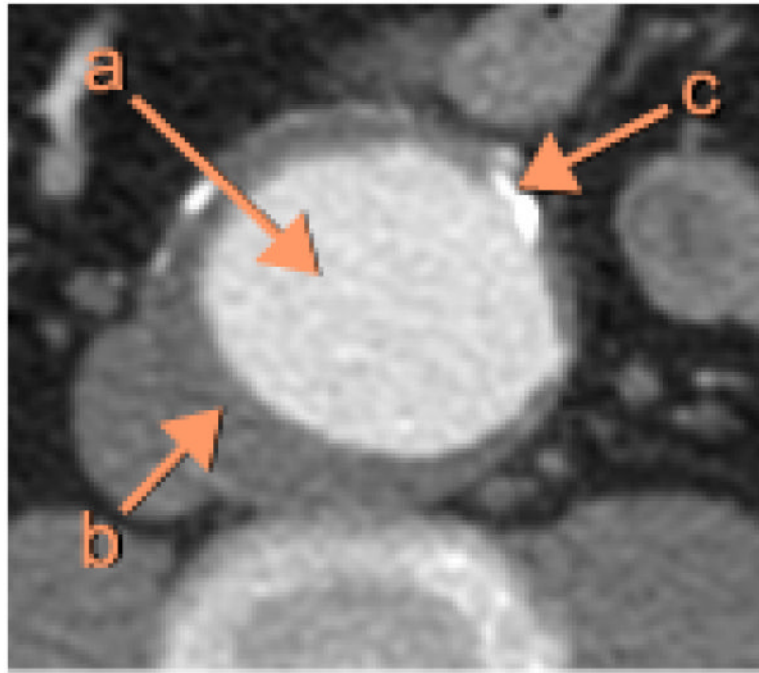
Example of an abdominal CTA image in AAA, cropped to show a section of the aorta. (a) Lumen. (b) Thrombus. (c) Calcification.
